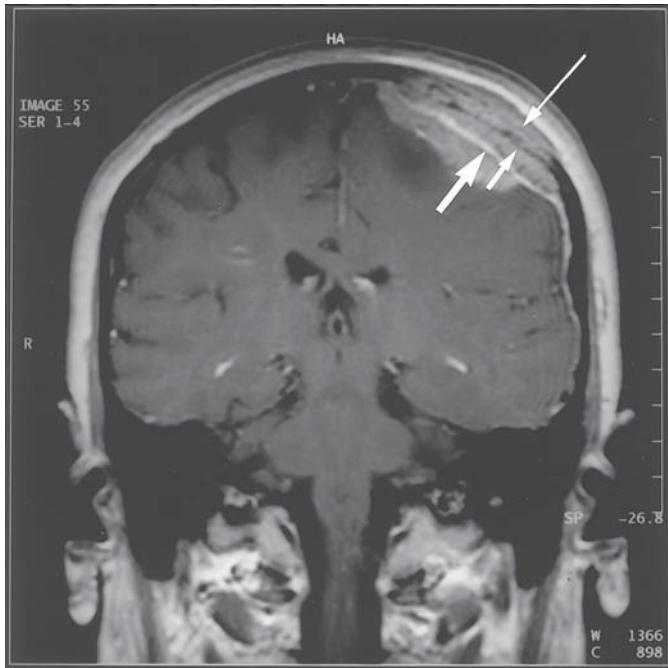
Calvarial metastasis with epidural and subdural tumor. The postcontrast T1-weighted MRI shows contrast enhancement of the calvarial lesion and epidural as well as subdural tumor extension. Contrast enhanced dura, thick arrow. Tabula externa, thin arrow. Tabula interna, small arrow.
